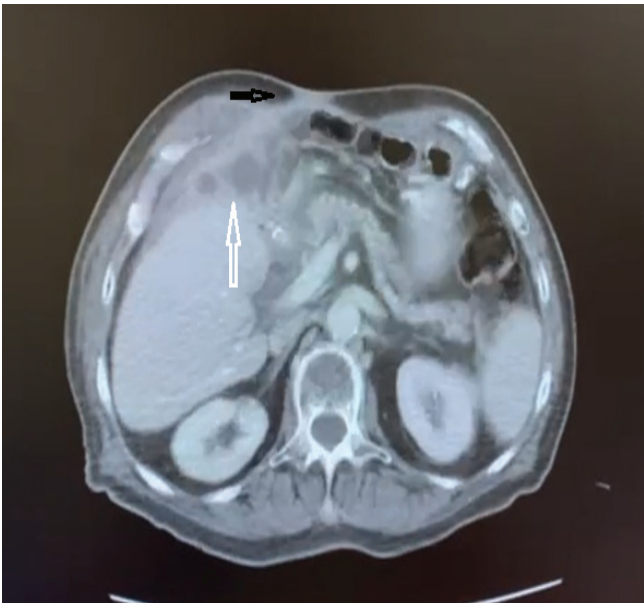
A section from the patient’s abdominal CT scan, black arrow: enterocutaneous fistula tract; white arrow: perihepatic abscess formation
